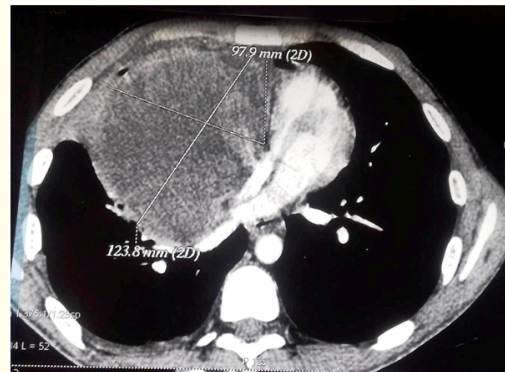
Thoracic computed tomography showing a heterogeneous mass of the anterior mediastinum of 12.5 cm compressing the right atrium and the superior vena cava associated with a right pleural effusion, a right hilar adenomegaly and centimetric right cardio phrenic nodes.
